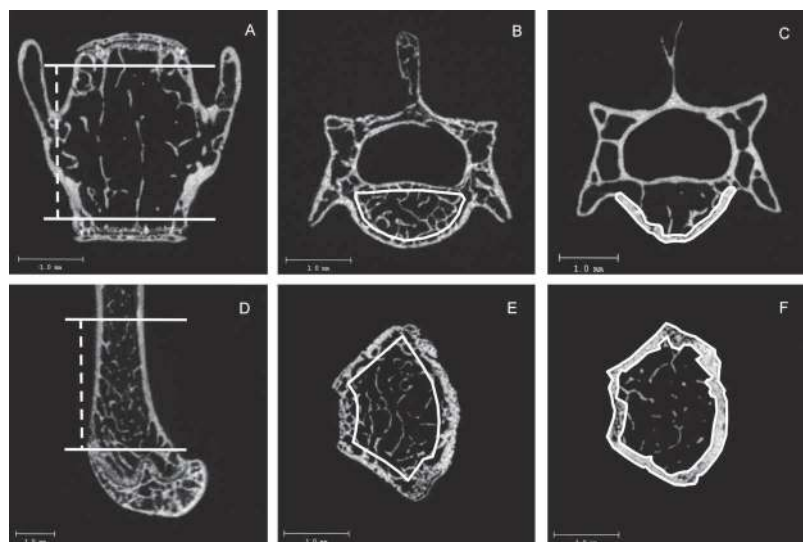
2D μ CT images showing regions of trabecular bone evaluation in the (A and B) lumbar vertebrae and (D and E) distal femur, along with example of how cortical bone region was outlined in the (C) vertebral body and (F) distal femur.
